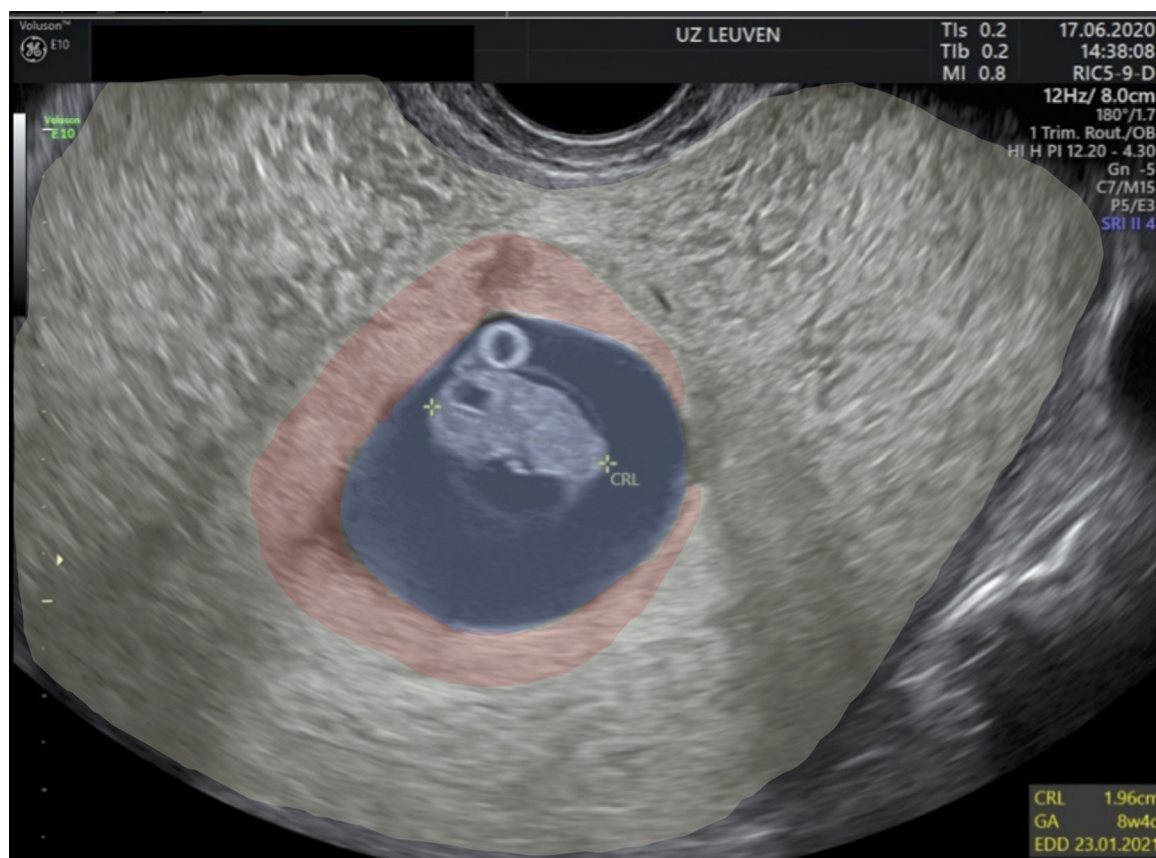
Transvaginal ultrasound image upon referral of the patient at 8 weeks and 4 days showing the gestational sac (blue), the developing placenta (red) and the diffusely thickened myometrium due to venous plexuses (yellow). (For interpretation of the references to color in this figure legend, the reader is referred to the web version of this article.).
